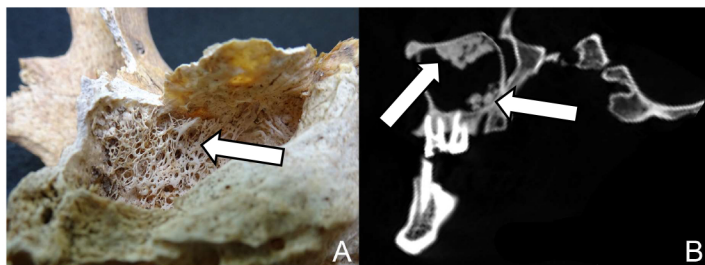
Bone growth associated with CMS. A) Macroscopical view; B) CT view
